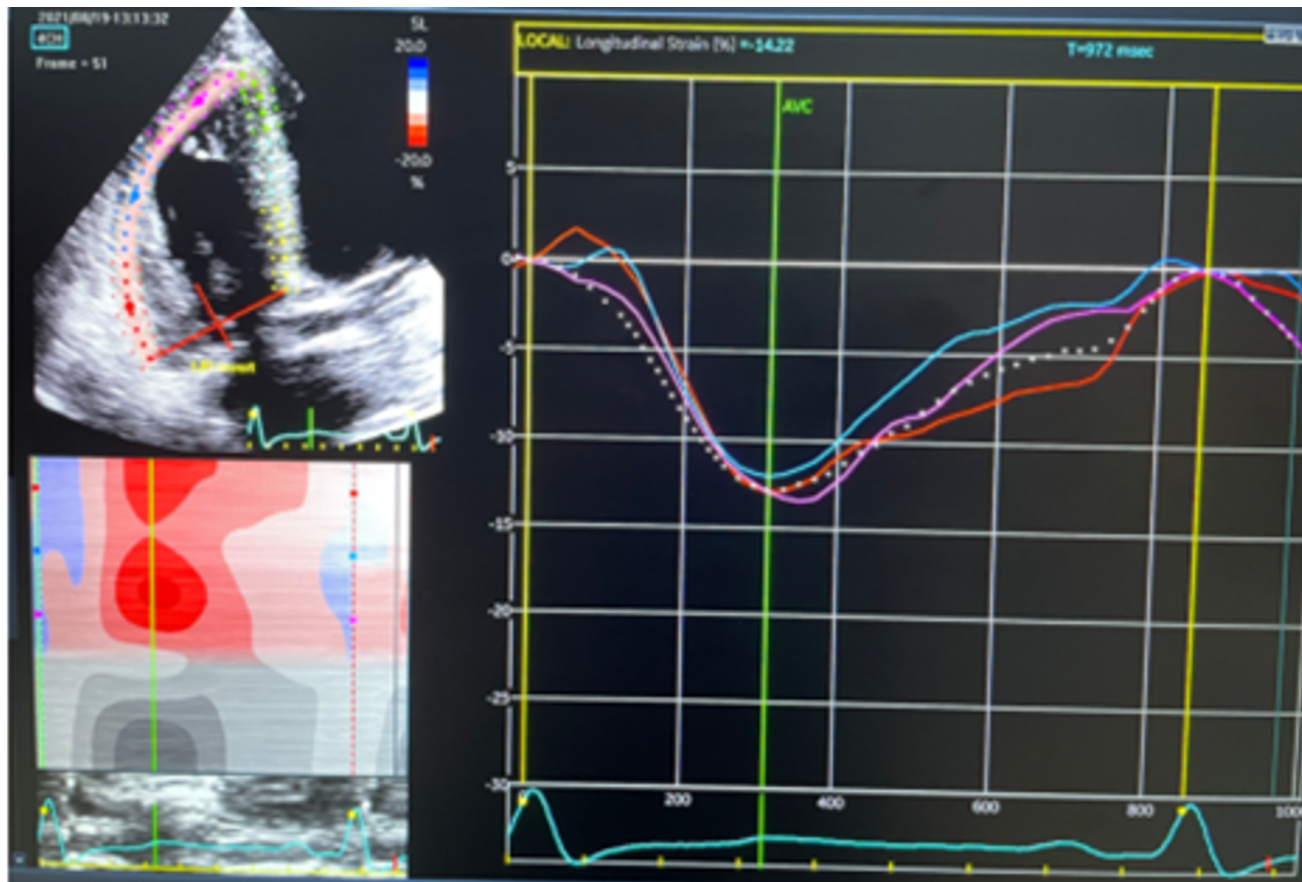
Speckle tracking echocardiography to assess RV-free wall GLS after RVOT stenting.
